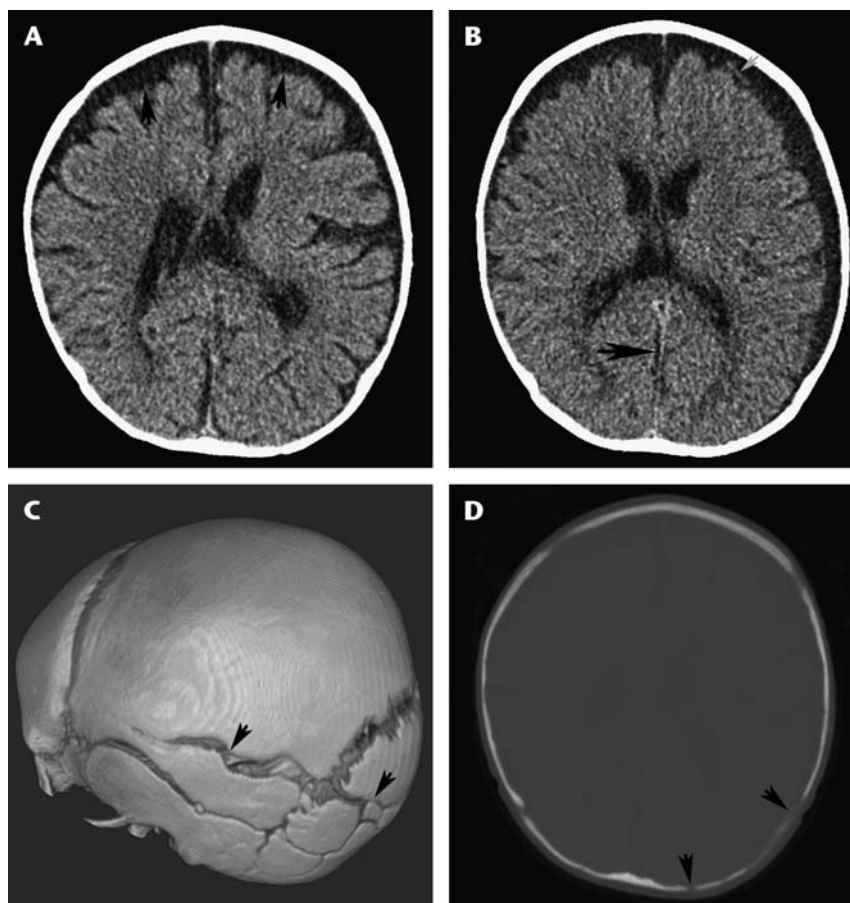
A, Axial images from the initial noncontrast CT head scan in a 9-month-old infant with failure to thrive and macrocephaly shows mildly increased bifrontal extra-axial fluid. B, Two weeks later, after a new seizure, axial images from a second noncontrast CT demonstrate acute subarachnoid (gray arrow) and subdural hemorrhages (black arrow) accompanied by sulcal effacement. C, 3-D reconstructions from this study demonstrated complex bilateral parietal-occipital fractures (arrows). D, In retrospect, 2-D bone windows from initial CT evaluation showed a subtle biparietal-occipital fractures [occipital and left parietal fractures (black arrows) on this slice].
